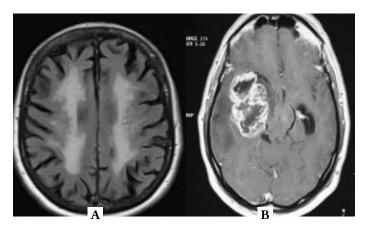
Sample T1-weighted contrast-enhanced axial MRI scans. (a) Normal brain (no tumor). (b) Brain with a tumor.
